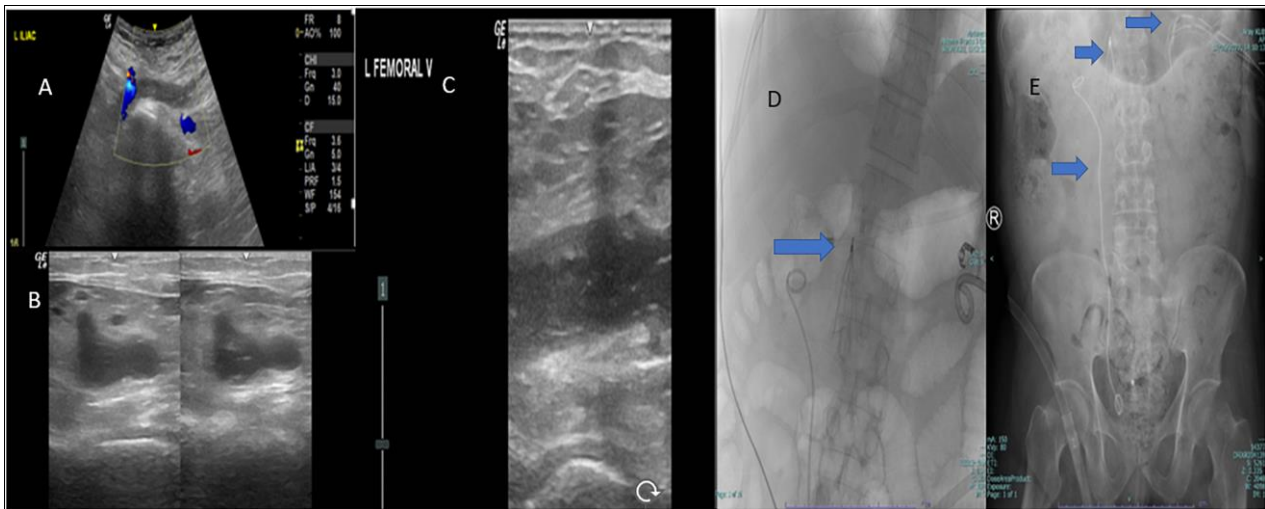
A, B, C: Venous Doppler showed distended iliofemoral veins with echogenic filling contents and absent Doppler flow suggestive of thrombosis. D: Denali IVC filter (arrow) was placed at infra-renal IVC by right trans jugular approach. E: Radiograph of KUB shows IVC filter, right DJ stent, and left pigtail drainage tube in situ (arrows pointing)
